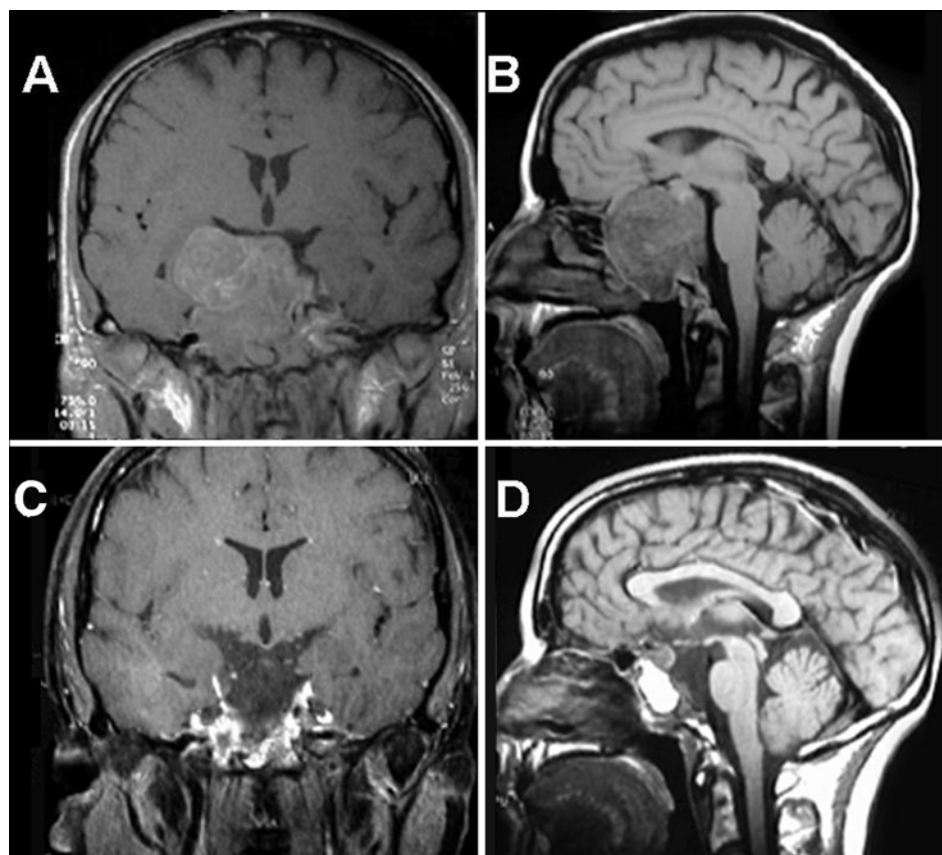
A and B: Preoperative coronal and sagittal MR images revealing a large chordoma with suprasellar extension that will be grossly removed through the anterior clivectomy. C and D: Postoperative coronal and sagittal T1-weighted enhanced MR images depicting tumor.
